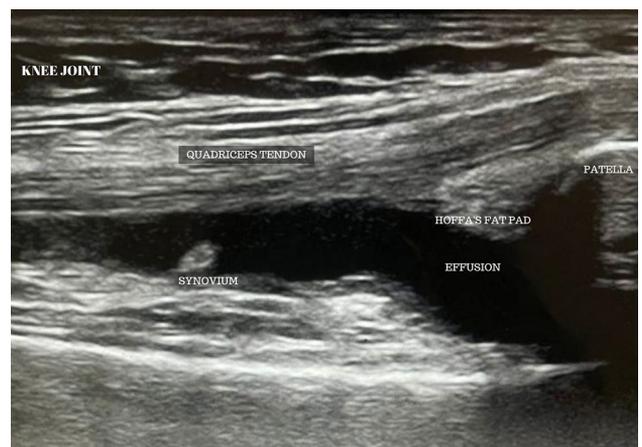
Appearance of synovial effusion in musculoskeletal ultrasound of osteoarthritis knee.
